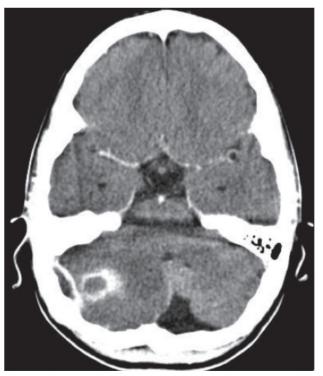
Contrast enhanced CT on soft tissue setting demonstrating an extradural abscess, Cerebellar abscess and surrounding cerebellar oedema.
